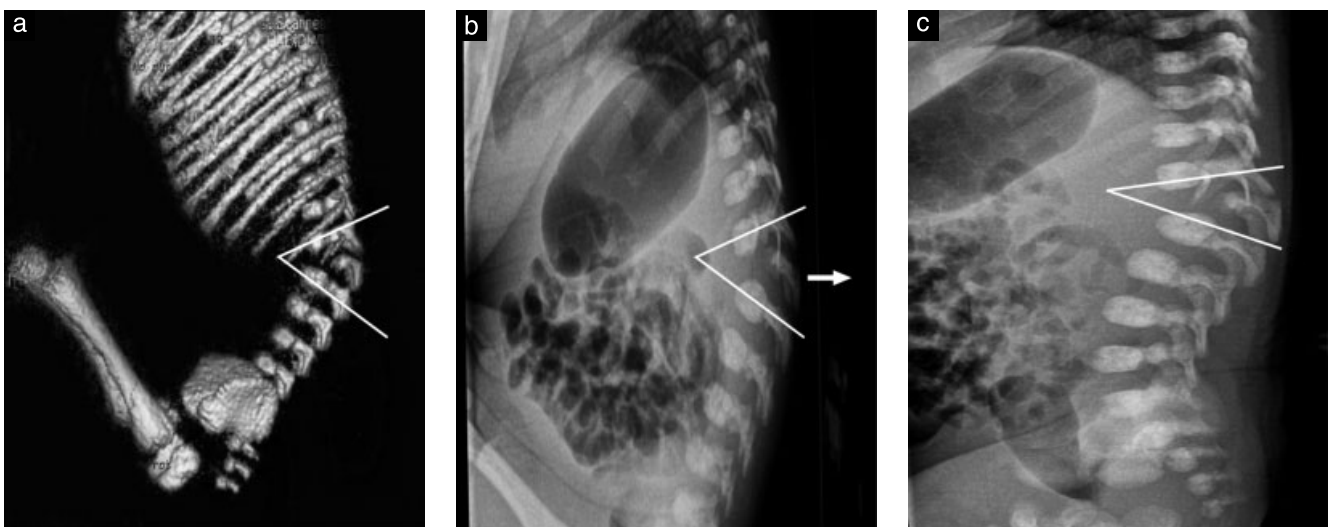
Three-dimensional bone reconstruction on computed tomography scan of the fetal trunk at 32 weeks' gestation, on which an angle of kyphosis of 70° was estimated (a). An identical angle was obtained by postnatal measurement on X-ray imaging in flexion conditions (70°) (b), but at rest the angle of kyphosis was only 30° (c).
